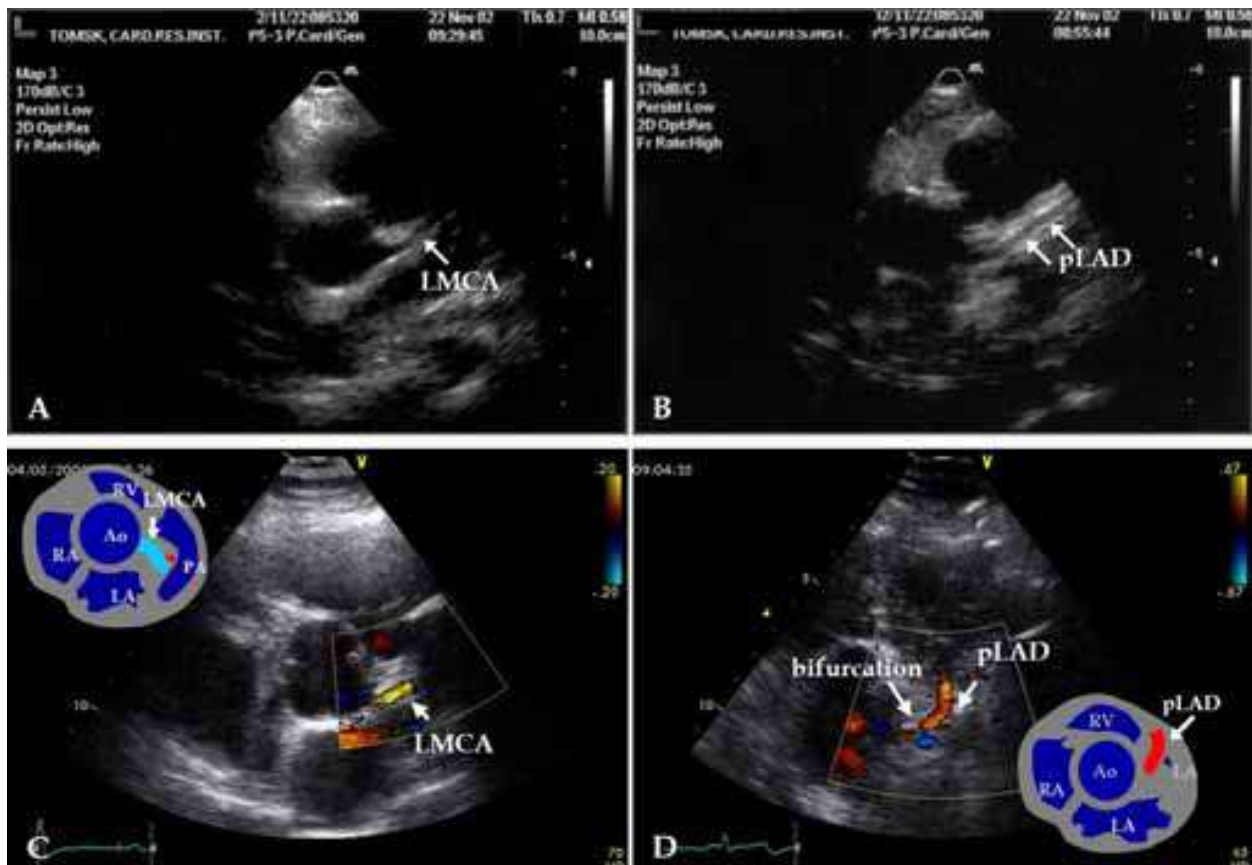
Images of the LMCA and proximal LAD (pLAD). The left parasternal position, a modified parasternal short axis view of great vessels, Nyquist limit is 20-67 cm/s. A – LMCA, B-mode; B – pLAD, B-mode; C – LMCA, Color Doppler mapping; D – bifurcation of the LMCA; Color Doppler mapping.
